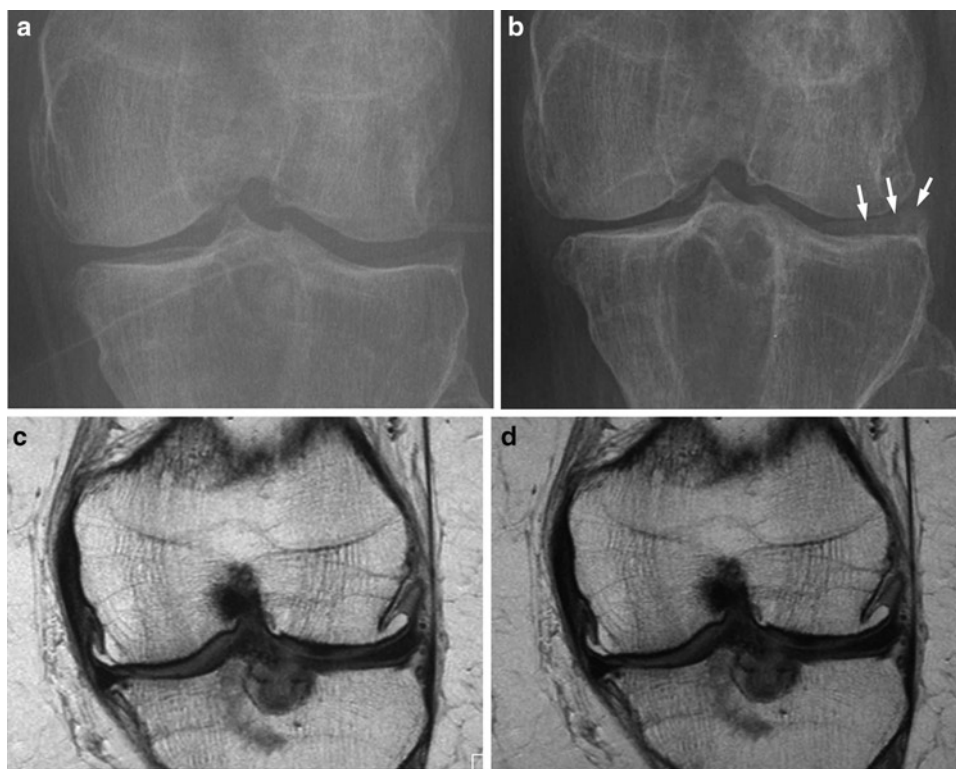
Progressive joint space narrowing (JSN) (a, b) but no progression on coronal intermediate-weighted MRI (c, d). Positioning from baseline to follow-up is slightly discordant. Lateral osteophyte projected
